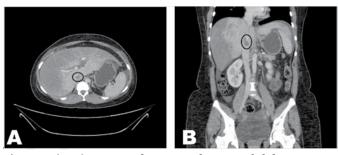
(A, B) Computed tomography scan of abdomen-Intra hepatic portion of inferior vena cava showing thrombosis as shown in circle.
